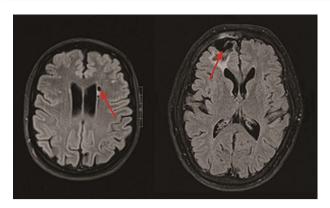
Magnetic resonance images (FLAIR sequence) of the brain a subependymally infarction (arrow left), and a frontal cortical infarction (arrow right).
